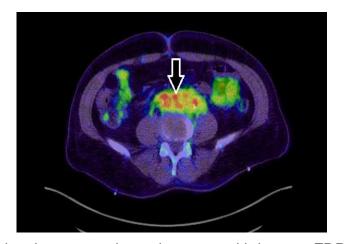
PET CT scan showing retroperitoneal mass with intense FDP uptake
